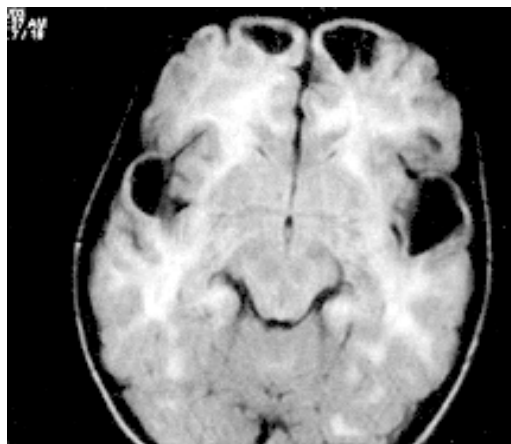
MRI brain showing bilaterally symmetrical white matter changes and cysts in frontal and anterior temporal region.
